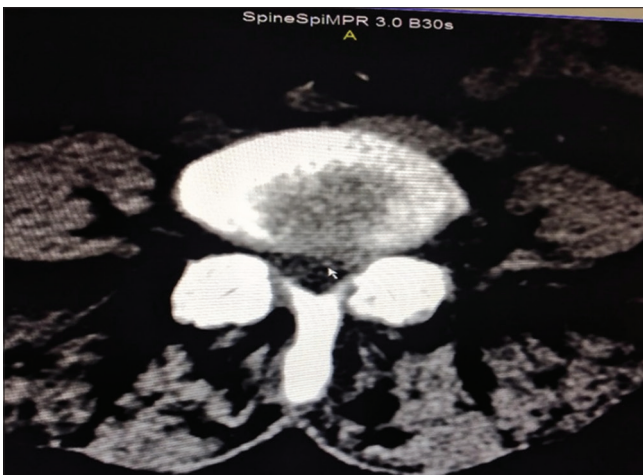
Patient with the left lower back pain. The CT scan shows the left lateral herniated disk Grade I in the L3-L4 intervertebral space
